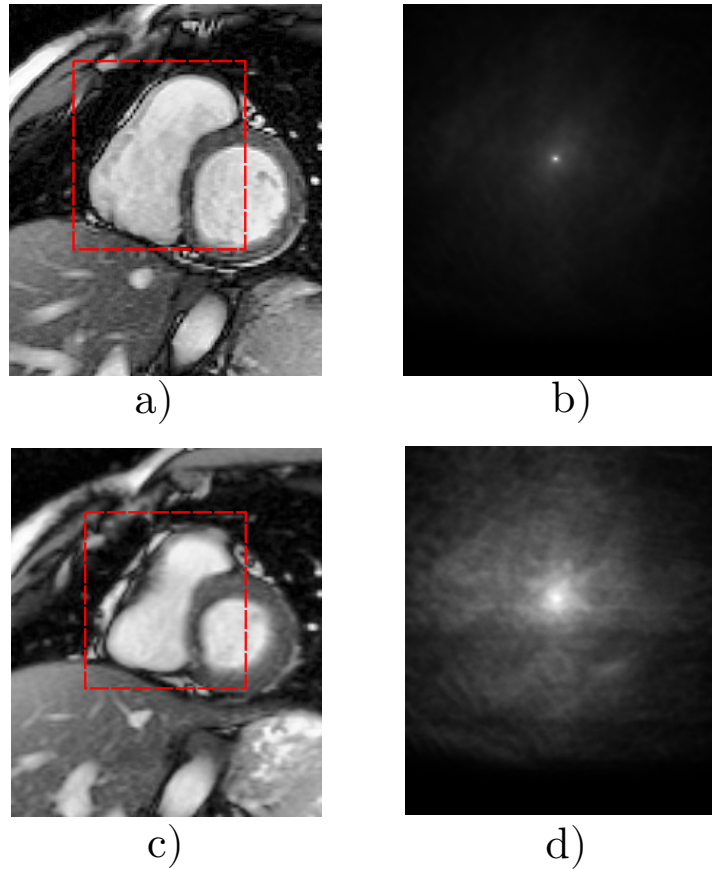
Hough model updating. a) Diastole cine-MRI; b) Diastole Voting map ; c) Systole cine-MRI; d) Systole voting map
